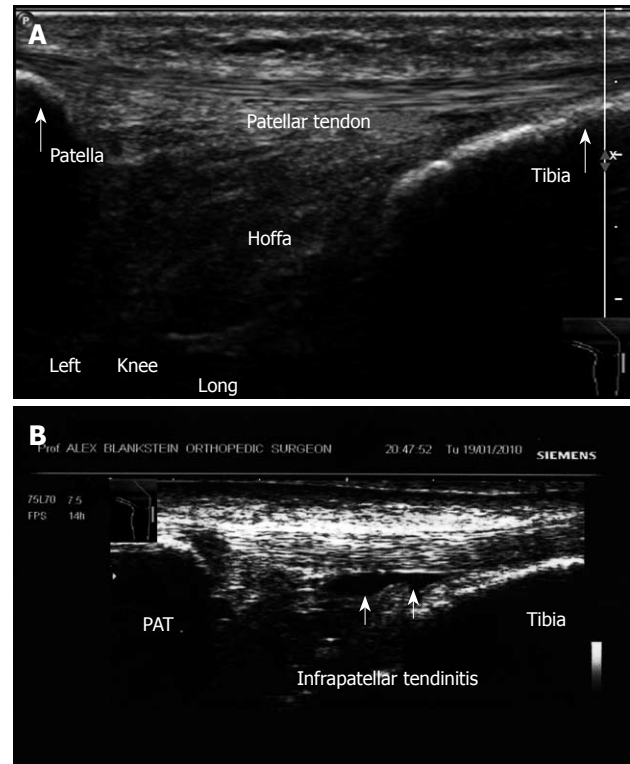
Patellar tendon. A: Longitudinal view. Anterior aspect. Ultrasound image shows the patellar tendon from its origin in the patella into the tibial tuberosity left knee; B: Infrapatellar tendinitis. Note fluid accumulation deep to the patellar tendon.
